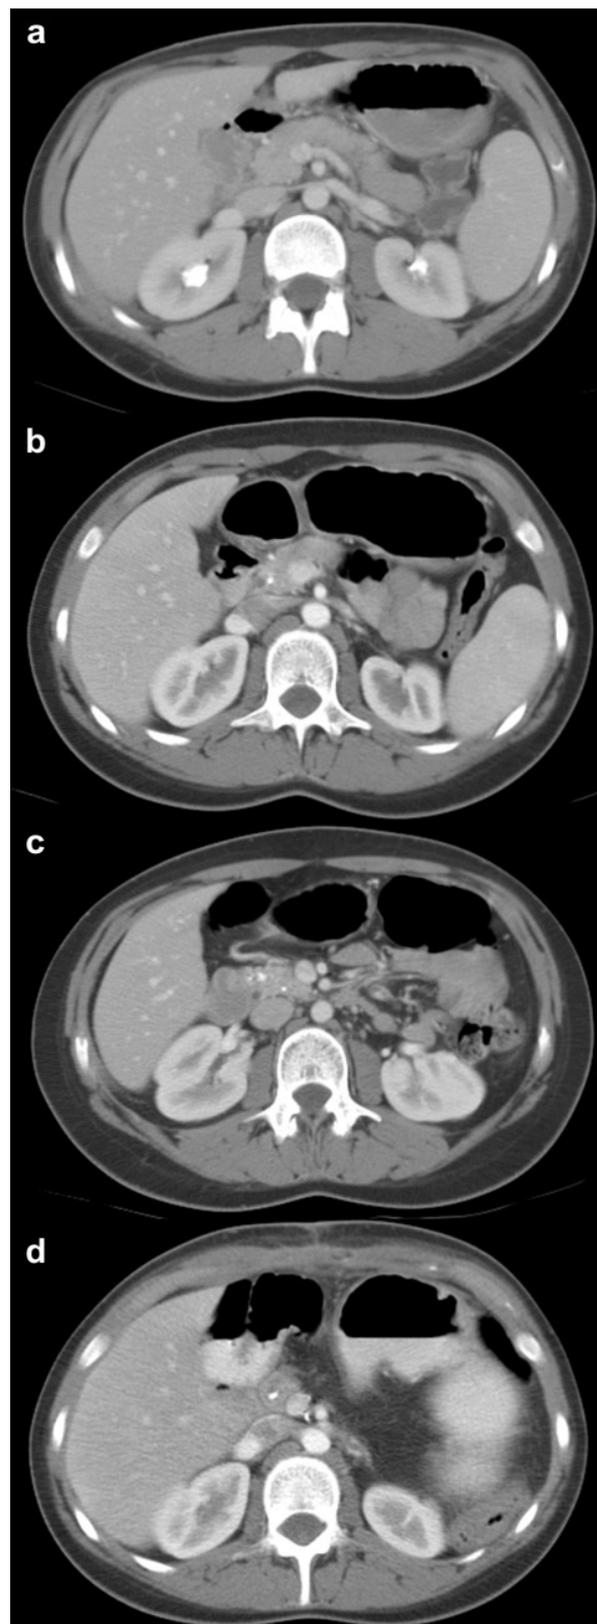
Progressive serial CT scans over 6 years (Patient A). a. Initial presentation CT does not show any evidence of chronic pancreatitis. b. c. Progressive calcification identified suggestive of chronic pancreatitis. d. Following pancreatectomy and pancreatic islet cell autotransplantation.
